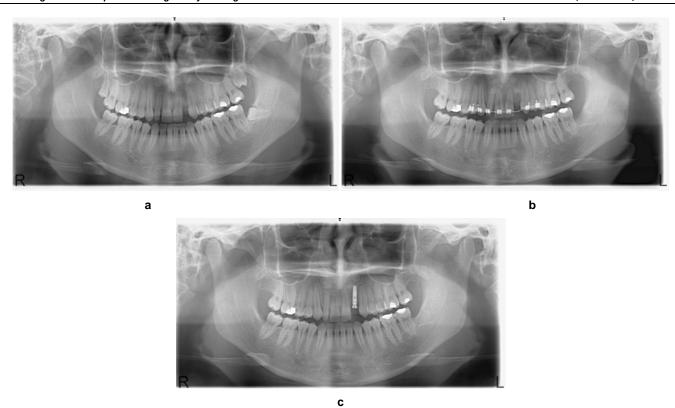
a: The lateral space had been opened for implant placement in a former orthodontic treatment. However, as the skeletal growth had not been completed, implant placement was postponed. Meanwhile, the neighboring teeth closed the space. b: The panoramic radiography during the course of orthodontic treatment. c: Lateral implant was inserted in the positioned area.
